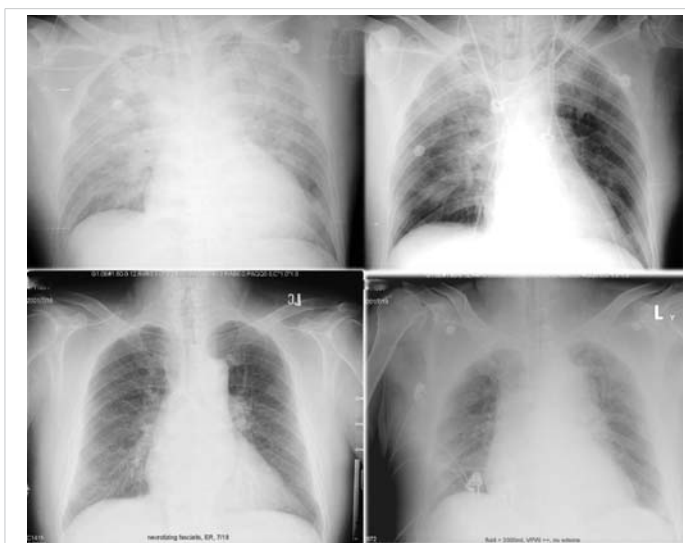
Radiographic examples of fluid balance and overload. Top row (same patient): left, input/output +1000 mL; right, I/O -1000 mL. Bottom row (different patient, necrotizing fasciitis with fluid overload): widened VPW and reduced lung transparency consistent with congestion.
